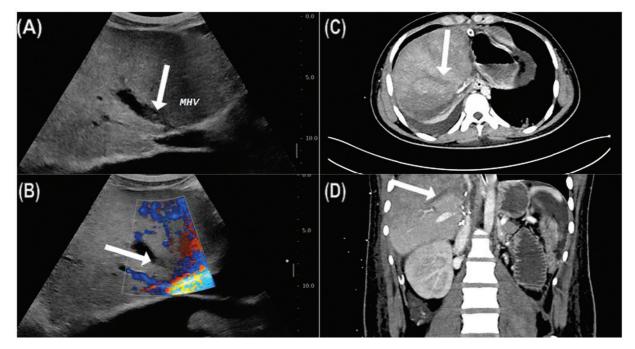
A 62-year-old male patient—post-deceased donor liver transplantation (DDLT) on 6th postoperative day (POD) routine Doppler surveillance. Ultrasound (USG) B-mode image (A) shows iso- to hyperechoic intraluminal thrombus (white arrow) within the right hepatic vein with no color uptake in Doppler image (B). Contrast-enhanced computed tomography (CECT) axial and coronal sections (C and D) of the upper abdomen of the same patient shows nonopacification in the right hepatic vein (white arrow) in the venous phase.
